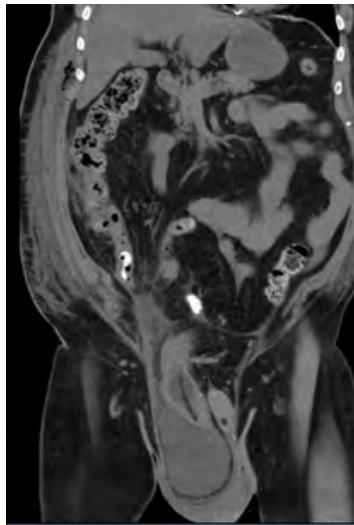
CT abdomen and pelvic extensive inflamed peritoneal wall with intra peritoneal fat stranding involved the bowel and bowel wall thickening.
